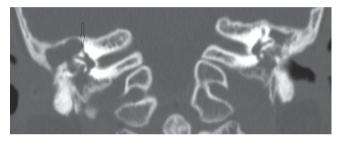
A coronal CT image of the same patient as in Fig. 12.6. The superior semicircular canal fistula is marked with a *black arrow*. (Copyright held by Dennis S. Poe, MD, PhD, Boston Children's Hospital)
